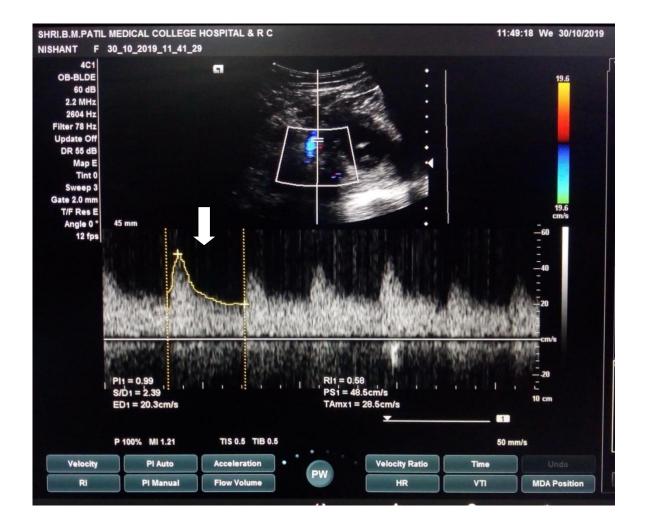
Uterine Artery Doppler showing normal uterine artery wave form (arrow)
